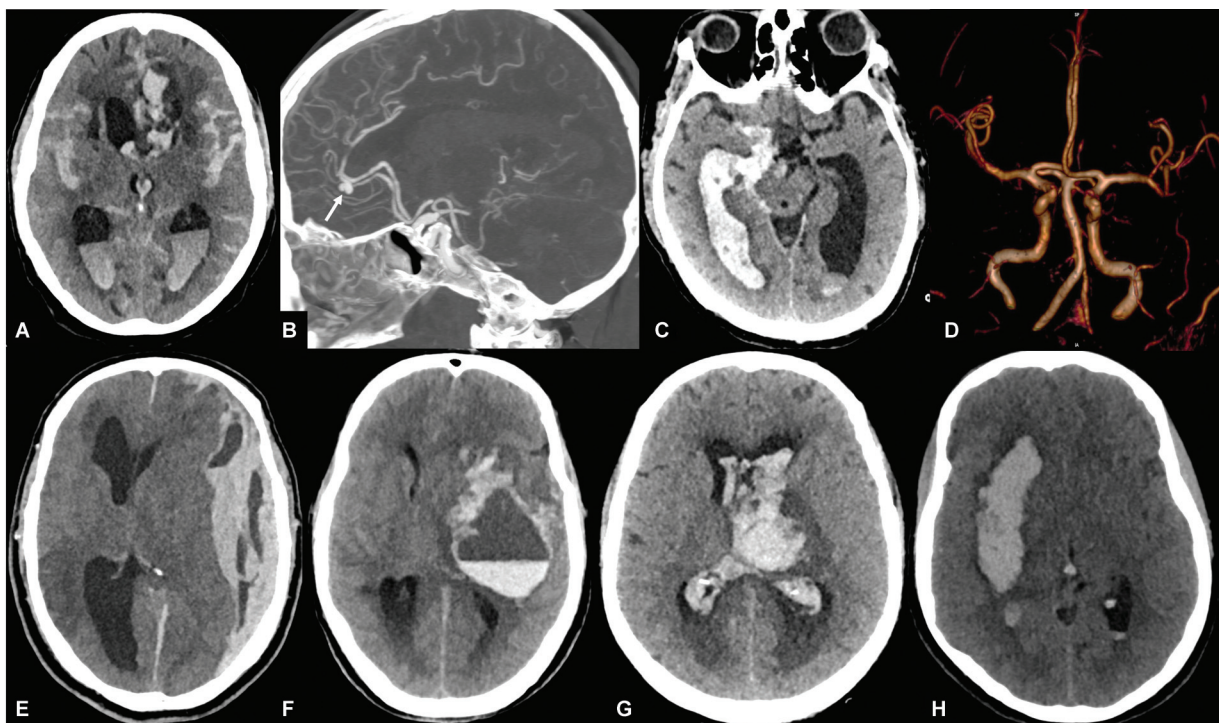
The hemorrhagic manifestations of coronavirus disease 2019 (COVID-19) infection. A 76-year-old female with severe headache and altered sensorium (A and B) showed diffuse subarachnoid hemorrhage and left distal anterior communicating artery aneurysm (arrow). A 65-year-old male, COVID-19 positive, presents with severe headache. Imaging revealed (C and D) subarachnoid hemorrhage at right side of suprasellar and crural cistern with intraventricular extension. The volume rendered images of magnetic resonance angiogram do not reveal any aneurysm, consistent with angioneegative subarachnoid hemorrhage. Image (E) shows a large left frontoparietal subdural hemorrhage with fluid levels in a 75-year-old patient with COVID-19 infection. The axial computed tomographic image (F) shows a large left gangliocapsular hematoma with hematocrit effect in a 40 years old male patient, who was on anticoagulation because of raised D-dimer levels. The image (G) and (H) show two young patients (28 and 17 years, respectively) presenting with intraparenchymal hemorrhage during their ongoing COVID-19 infection.
